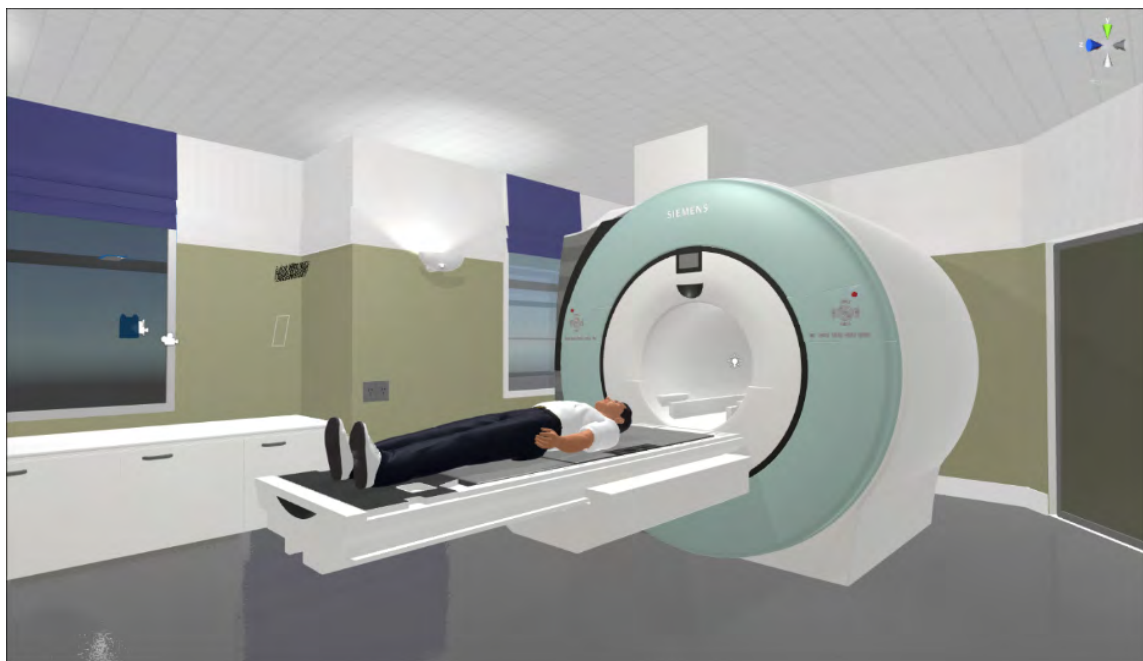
Prototype 3D model of MRI scanner
